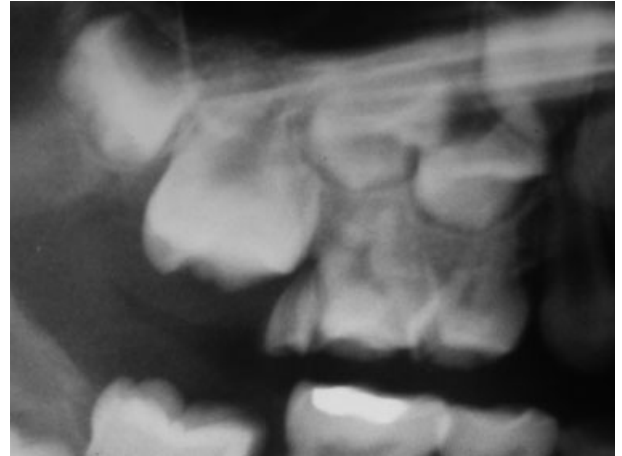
Periapical radiograph: crown fracture at distal aspect of tooth 55.
